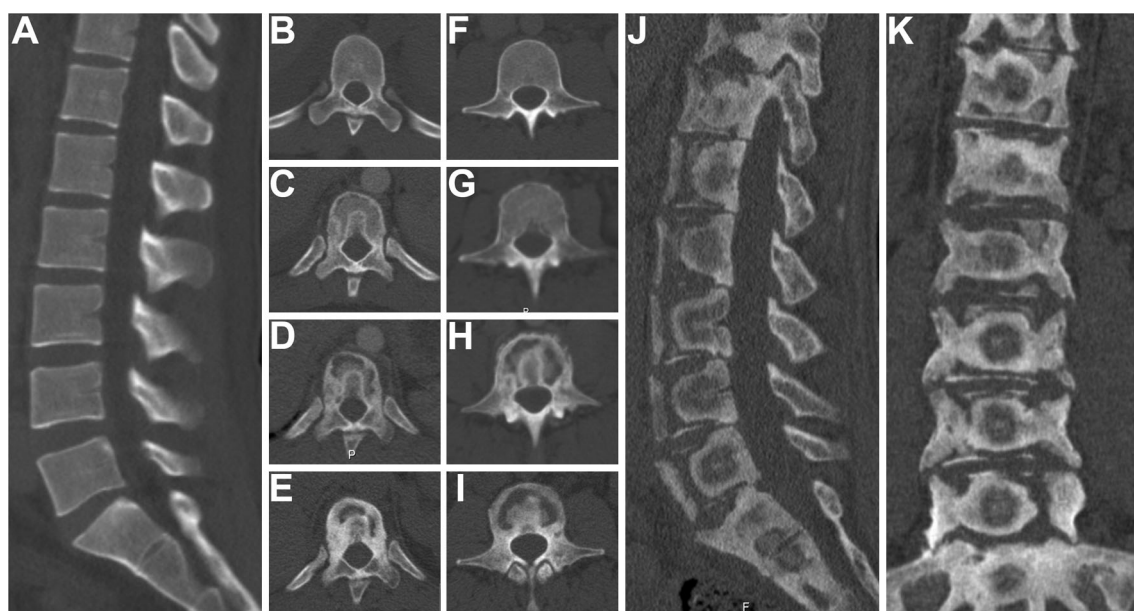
Sagittal (a, j), axial (Th11, b–e and L3, f–i) and coronal (k) computed tomographic images showing the patient's lumbar spine in chronological order. The scans were taken 3 days after admission (a, b, f), 1.5 months (c, g), 6 months (d, h) and 16 months (e, i–
